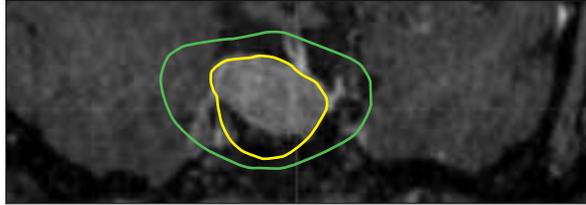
Postgadolinium coronal MRI of a patient with acromegaly demonstrating the radiation dose plan for radiosurgery. The tumor margin dose (yellow line) receives 20 Gy, whereas the outer green line receives 20% (8 Gy) of the maximum radiation dose (40 Gy). The maximum dose to the adjacent optic nerves is 9.2 Gy.
